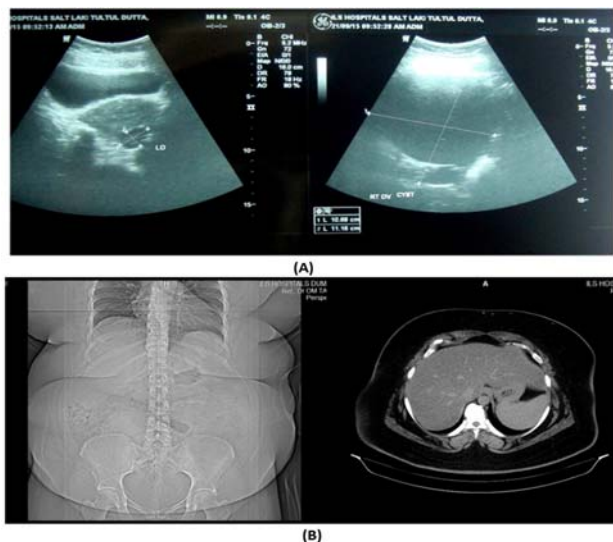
(A) USG: Large complex multiloculated right ovarian cyst with septations and solid components. (B) – CT scan of lower abdomen: The large multiloculated cystic space occupying lesion (SOL) in the right adnexa showing internal density.
